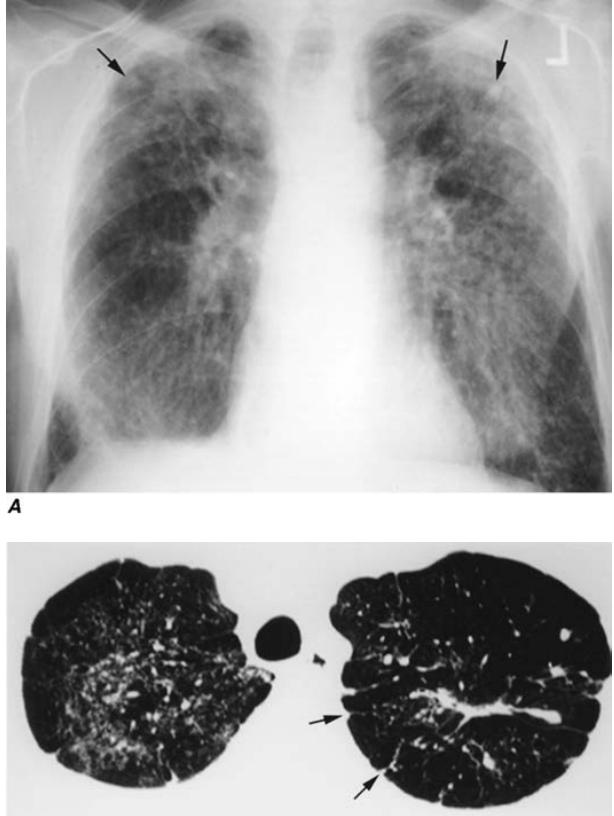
Chronic silicosis. A. Frontal chest radiograph in a patient with silicosis shows variably sized, poorly defined nodules (arrows) predominating in the upper lobes. B. Axial thoracic computed tomography image through the lung apices shows numerous small nodules, more pronounced in the right upper lobe. A number of the nodules are subpleural in location (arrows).
